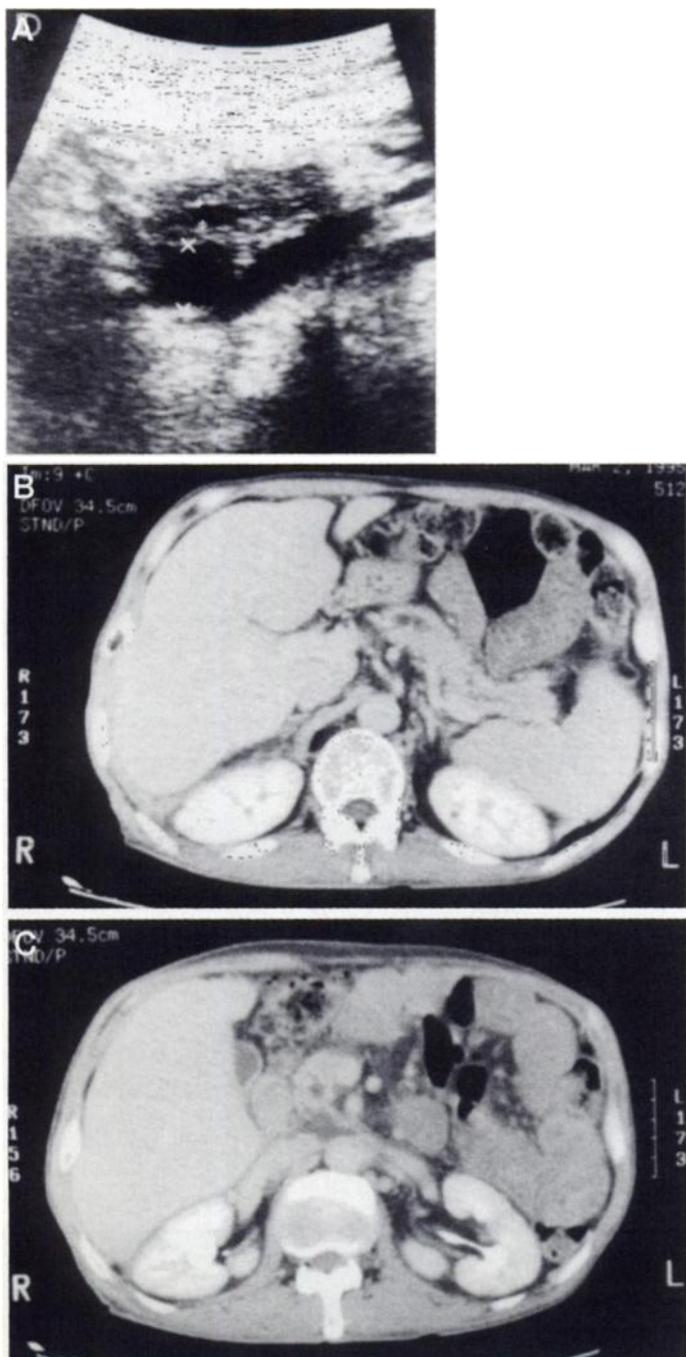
(A) Sonogram and (B and C) CT scans of the abdomen show enlarged pancreas, pseudocyst at the pancreatic head and dilated pancreatic duct.
